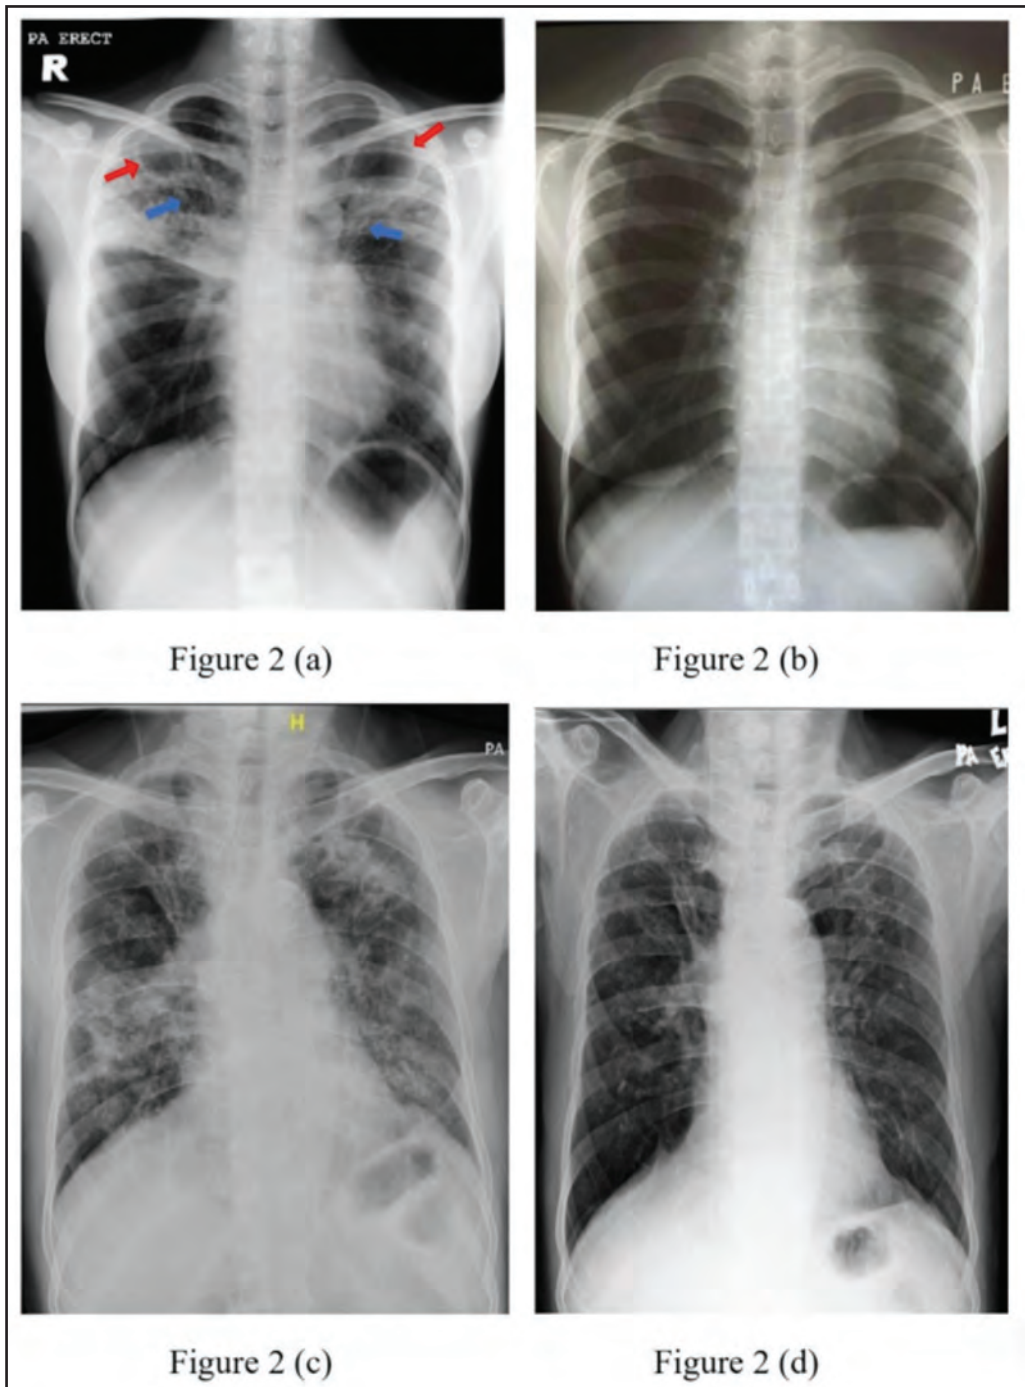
(a) Pre treatment chest radiograph for Case 4
